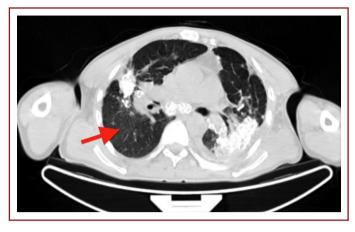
Complicated silicosis in a 53-year-old stone worker. Axial high-resolution computed tomography (W:1500, C: –500) shows bilateral upper lobar massive fibrosis with pleuroparenchymal scarring and extensive calcification. There are also ill-defined micronodules on the right superior basal lobe (arrow) and eggshell calcifications on mediastinal lymph nodes.
